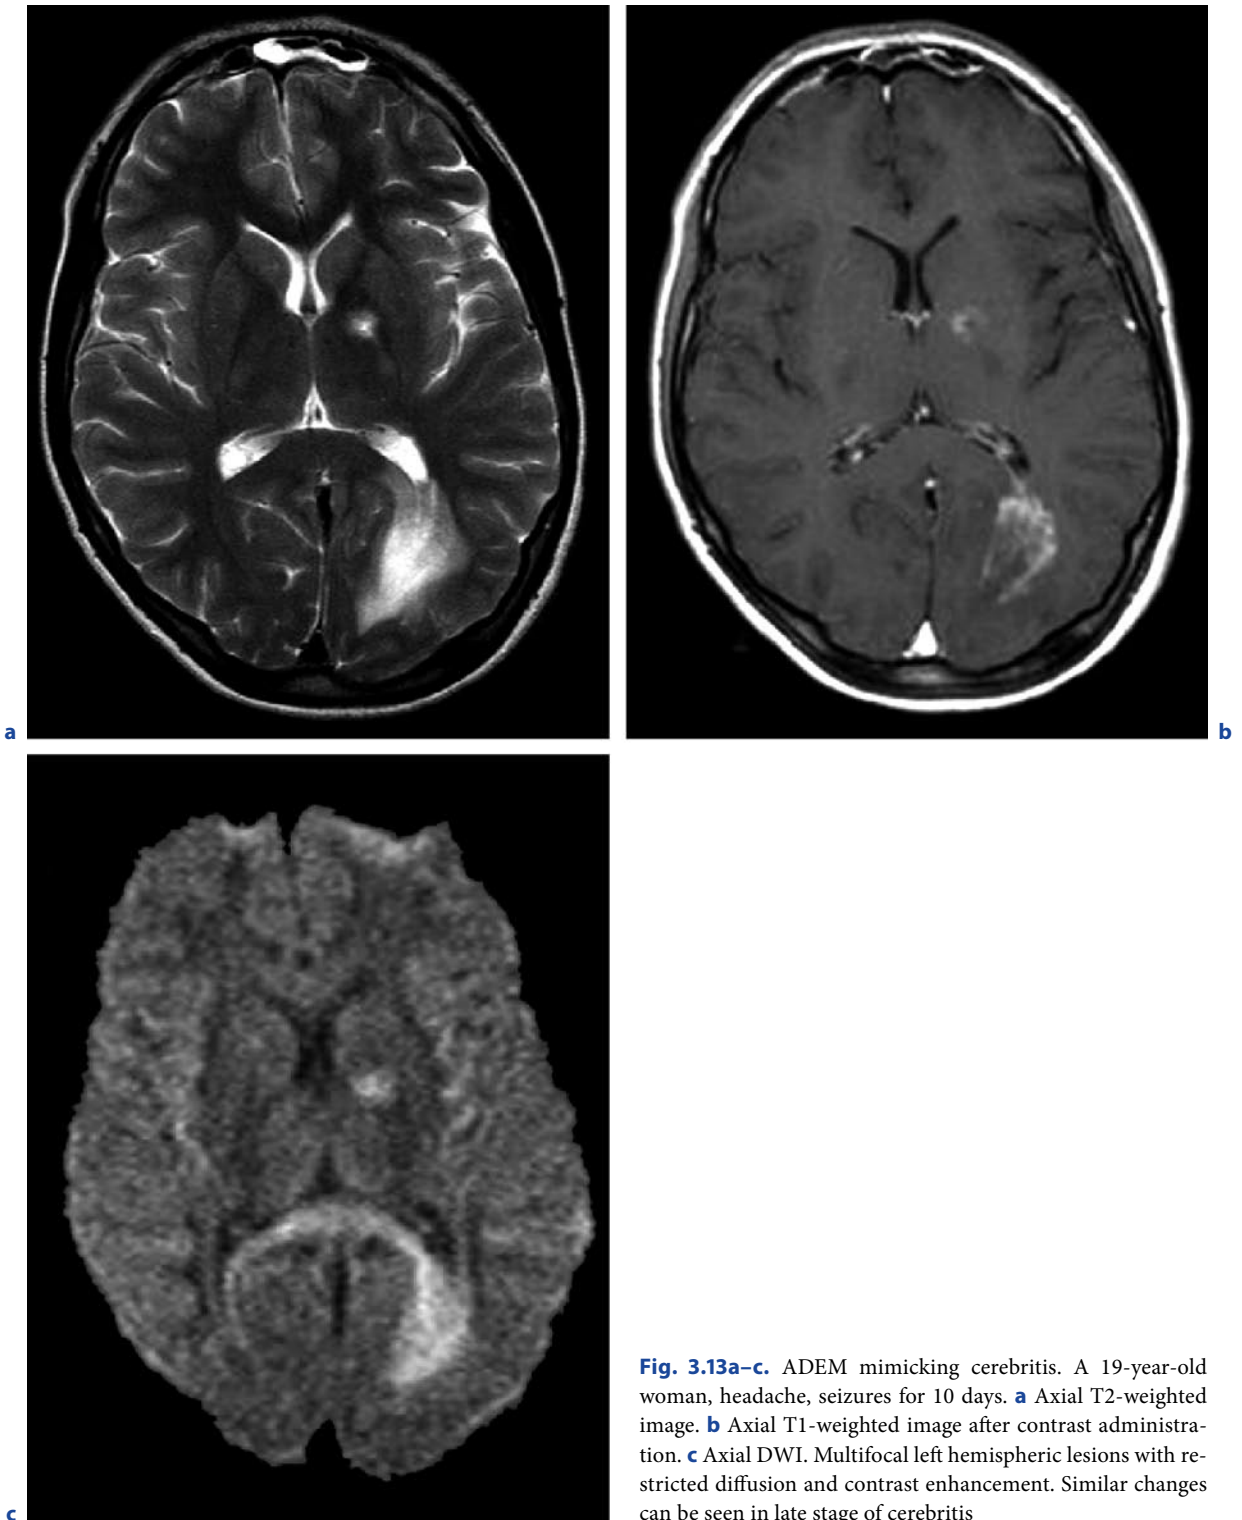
ADEM mimicking cerebritis. A 19-year-old woman, headache, seizures for 10 days. a Axial T2-weighted image. b Axial T1-weighted image after contrast administration. c Axial DWI. Multifocal left hemispheric lesions with restricted diffusion and contrast enhancement. Similar changes can be seen in late stage of cerebritis
